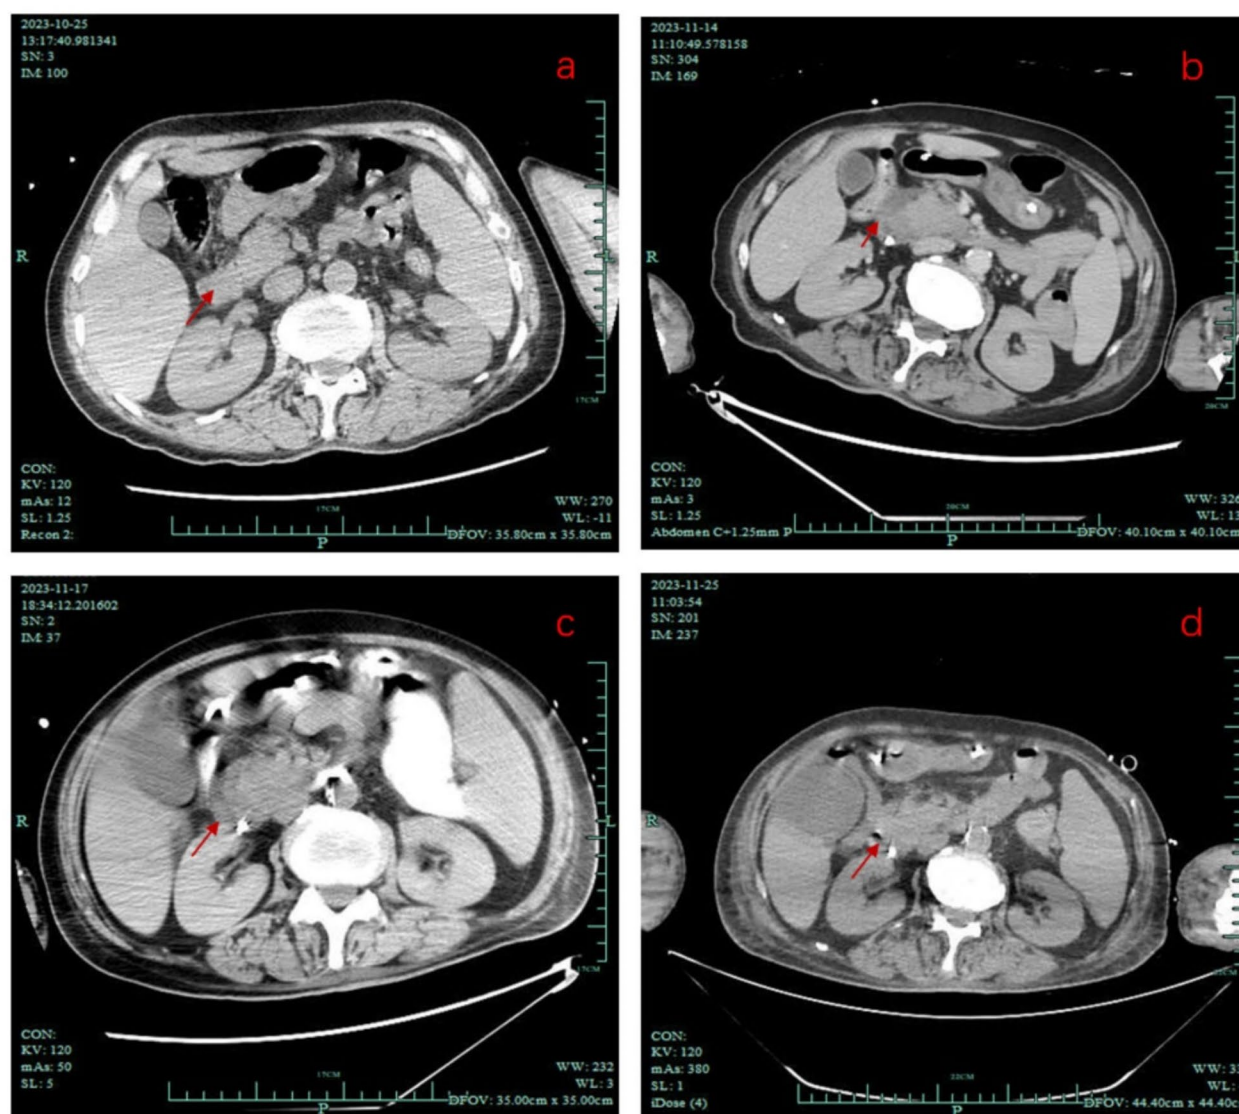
Patient's abdominal CT scan images before and after use of omadacycline. (a) no pancreatitis on the day of admission; (b) encapsulated fluid accumulation in the pancreatic head on 6 days after omadacycline; (c) slight exudation in the pancreatic head on 9 days after omadacycline; (d) disappearance of edema in the pancreatic head on 17 days after omadacycline
